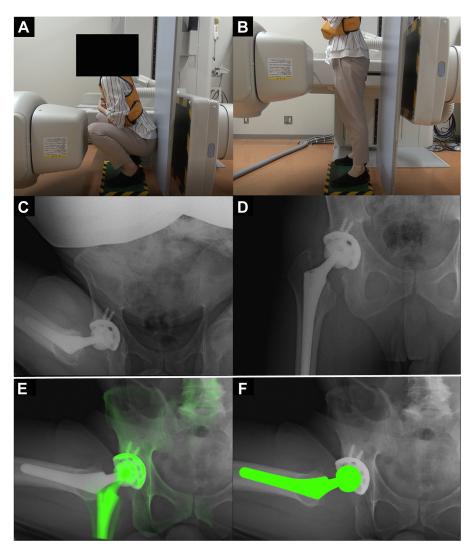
Patients who had undergone total hip arthroplasty stood from a squat position with their heels down (A, B). Hip motions during squatting were captured using a flat-panel X-ray detector (C, D). Digitally reconstructed radiographs of the pelvis and acetabular cup (E) and computer-aided data of the femoral head and stem (F) were super-imposed on radiographic images.
